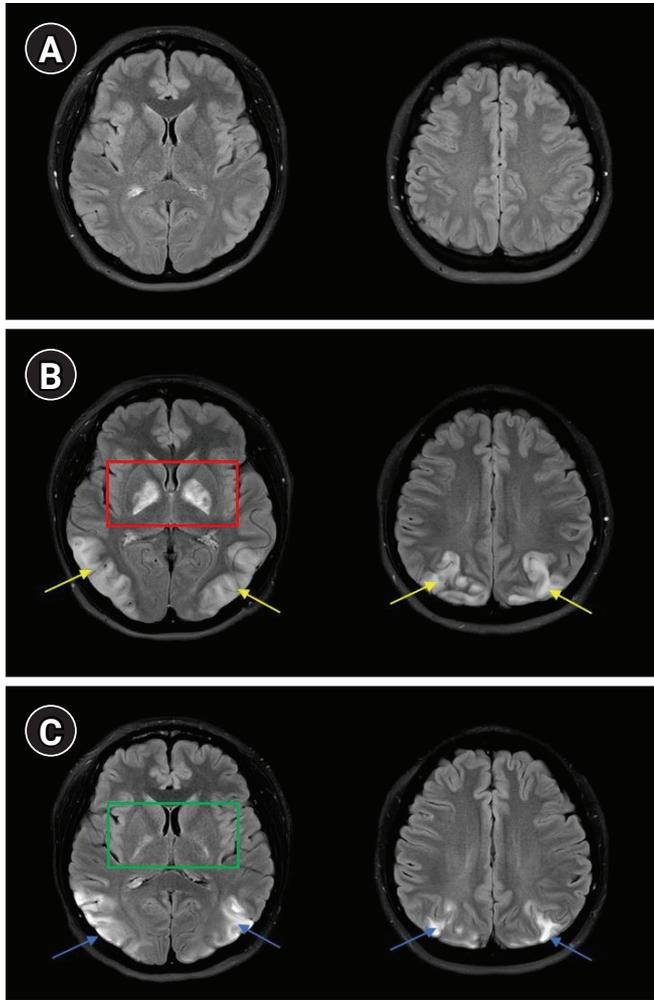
Brain magnetic resonance imaging. (A) The day of carbon monoxide (CO) poisoning, fluid-attenuated inversion recovery (FLAIR) images showed no abnormal high signal intensity. (B) Twelve days from CO intoxication, FLAIR images showed high signal intensities in bilateral globus pallidus (red box) and both parieto-occipital cortex (yellow arrows), suggesting posterior reversible encephalopathy syndrome. (C) Twenty-five days after CO intoxication, follow-up FLAIR image was obtained from the outpatient visit, and it showed interval decrease of signal and volume in bilateral globus pallidus (green box) and temporo-parieto-occipital cortex (blue arrows).
